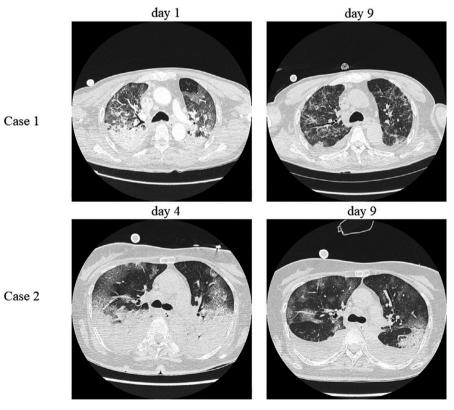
Chest computed tomography scans of two patients with COVID-19 treated with veno-venous extracorporeal membrane oxygenation (ECMO) and prone ventilation. Case 1, day 1: Ground-glass opacities and bilateral dorsal consolidation were visible. Case 1, day 9: Bilateral dorsal consolidation improved. Case 2, day 4: Ground-glass opacities and bilateral dorsal consolidation were visible. Case 2, day 9: Bilateral dorsal consolidation improved and bilateral pleural effusion.
